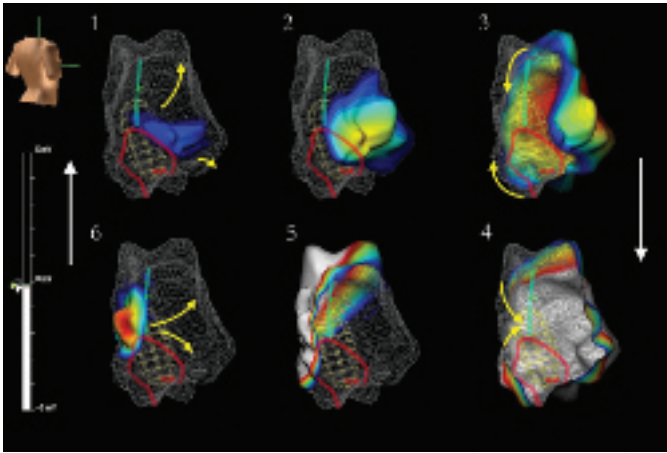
Isopotential maps depicting a macro-reentrant right atrial tachycardia following atriopulmonary Fontan. The right atrium (RA) is seen from the right posterior oblique view (torso denotes orientation). At the inferior aspect of the posterolateral wall an area of dense scar defined by simultaneous contact mapping (CARTO, Biosense Webster, Diamond Bar, CA) has been annotated to the noncontact reconstruction (red diamond outline). The possible position of the crista terminalis (CT) running from the scar to the superior aspect of the posterolateral wall has similarly been annotated (green line). During sinus rhythm activation was seen to proceed across the crista terminalis from the upper lateral to posterior wall. Amplitude of the local noncontact electrograms (EGM) are
